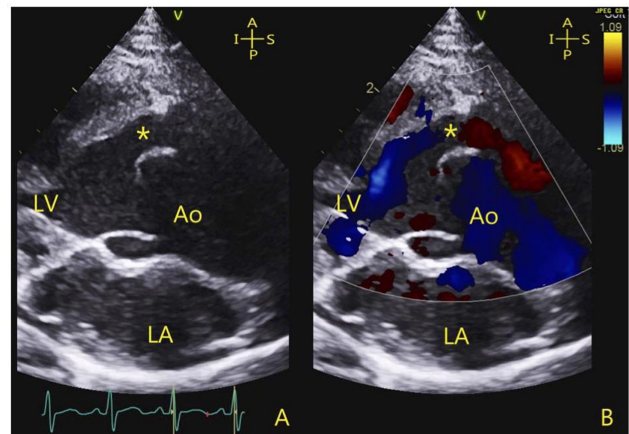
Colour doppler imaging of the ALVT(*) in a parasternal long axis view. Ao: aorta, LV: left ventricle, LA: left atrium.
